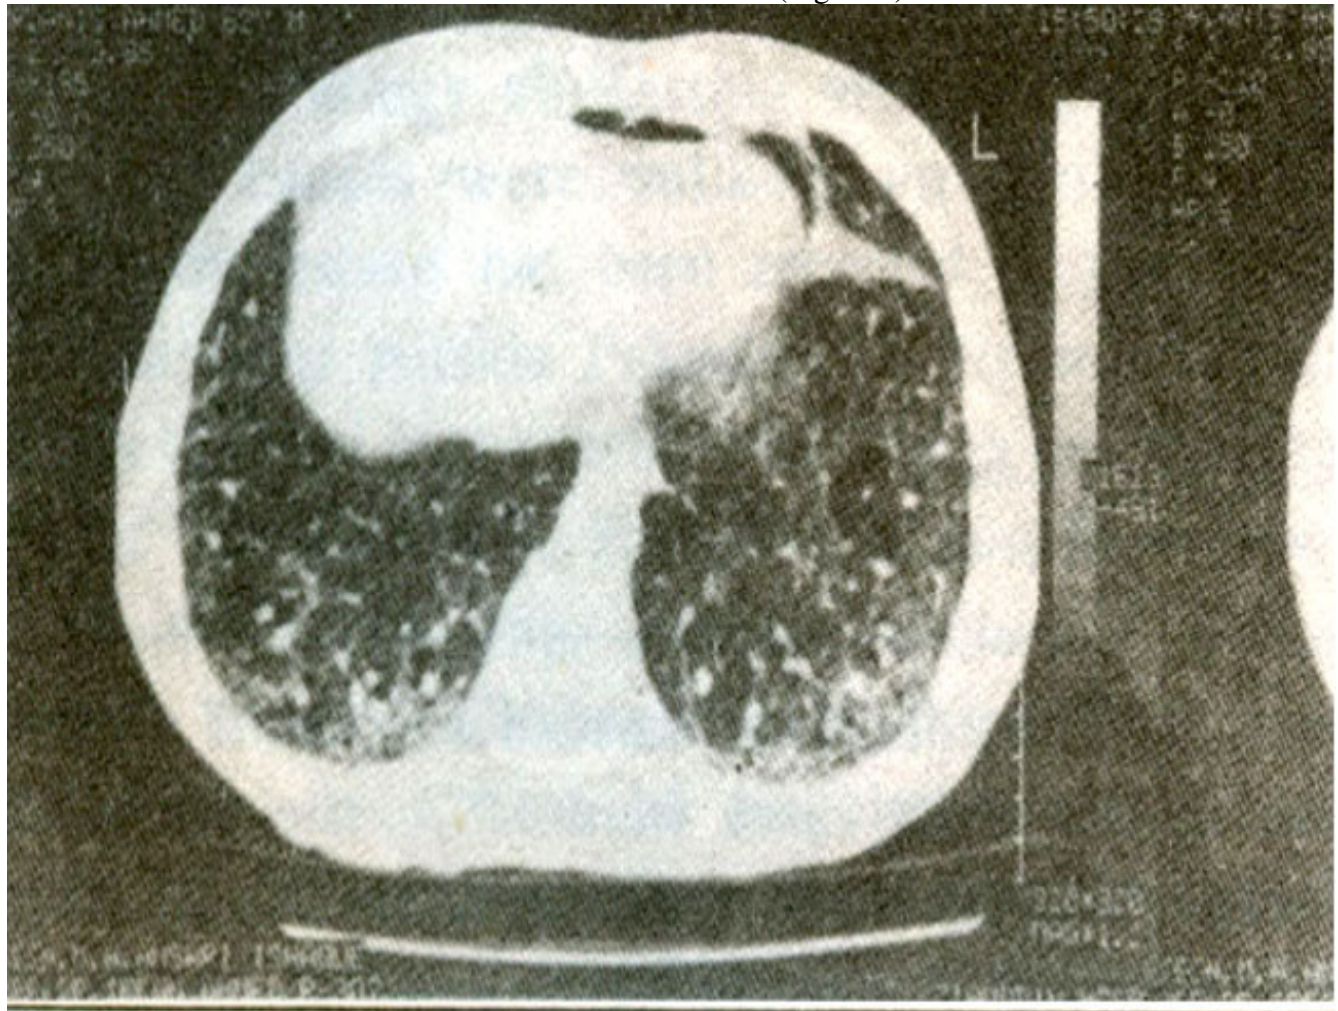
High resolution chest CT near the base of the lungs showing diffuse reticulo-nodular. Shadows, fibrosis and bronchiectasis.
